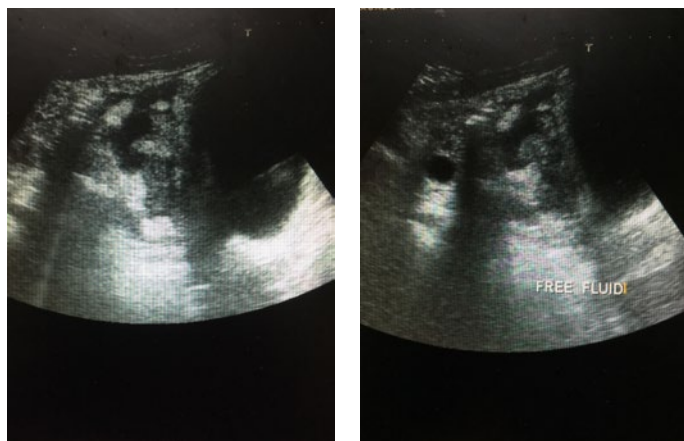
Ultrasound images showing the bladder on the right side of the images and clots on the left of the images. No uterus visible.
